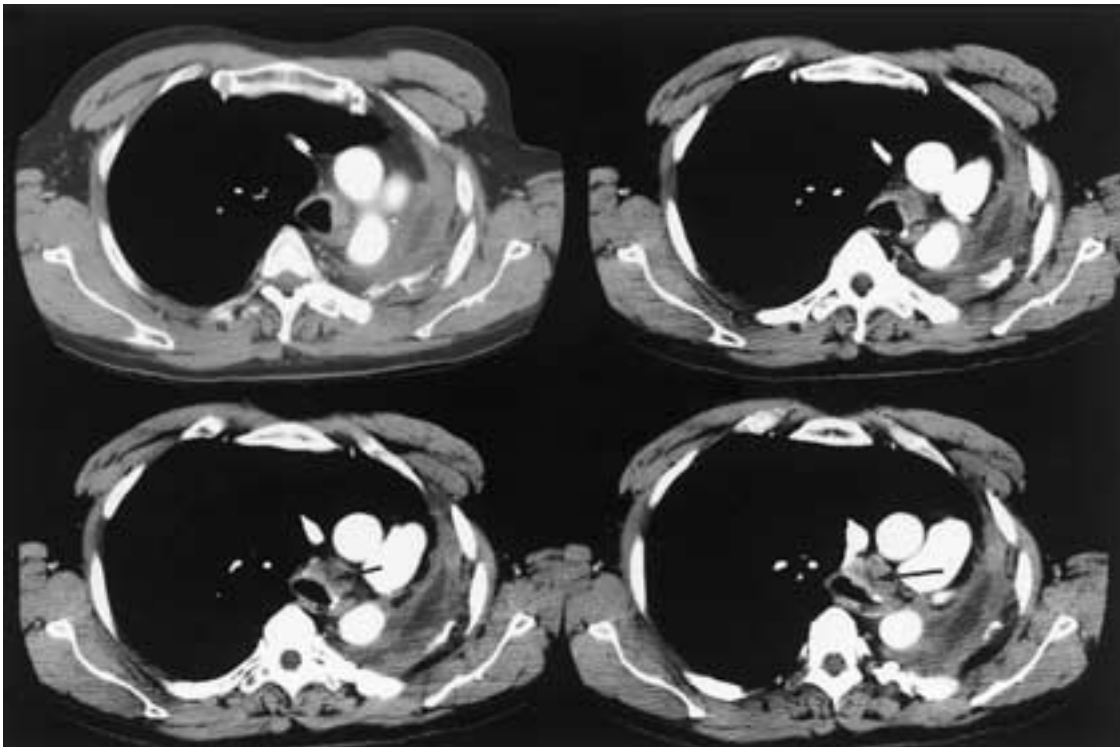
Recurrent squamous cell carcinoma at the carina. A 48-year-old male after pneumonectomy for SCC of the lung presented with cough and sputum production. Contiguous contrast-enhanced axial chest CT images demonstrate soft-tissue infiltration anterior to and to the left of the distal trachea extending to the carina (arrows). Irregularity of the anterior tracheal wall, carina, and left mainstem bronchus is indicative of neoplastic invasion. Postpneumonectomy changes are noted.
